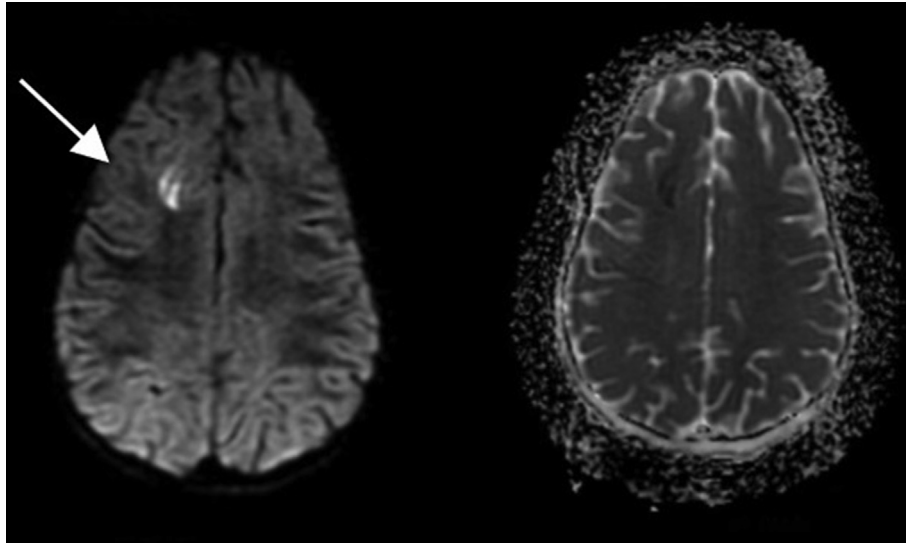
Axial MRI-DWI image (left) and corresponding ADC map (right) of a 3-year-old infant with SCD revealing focal high intensity lesions on DWI, and corresponding low signal on the ADC map, due to acute ischaemic lesions affecting the right frontal watershed arterial territory.
